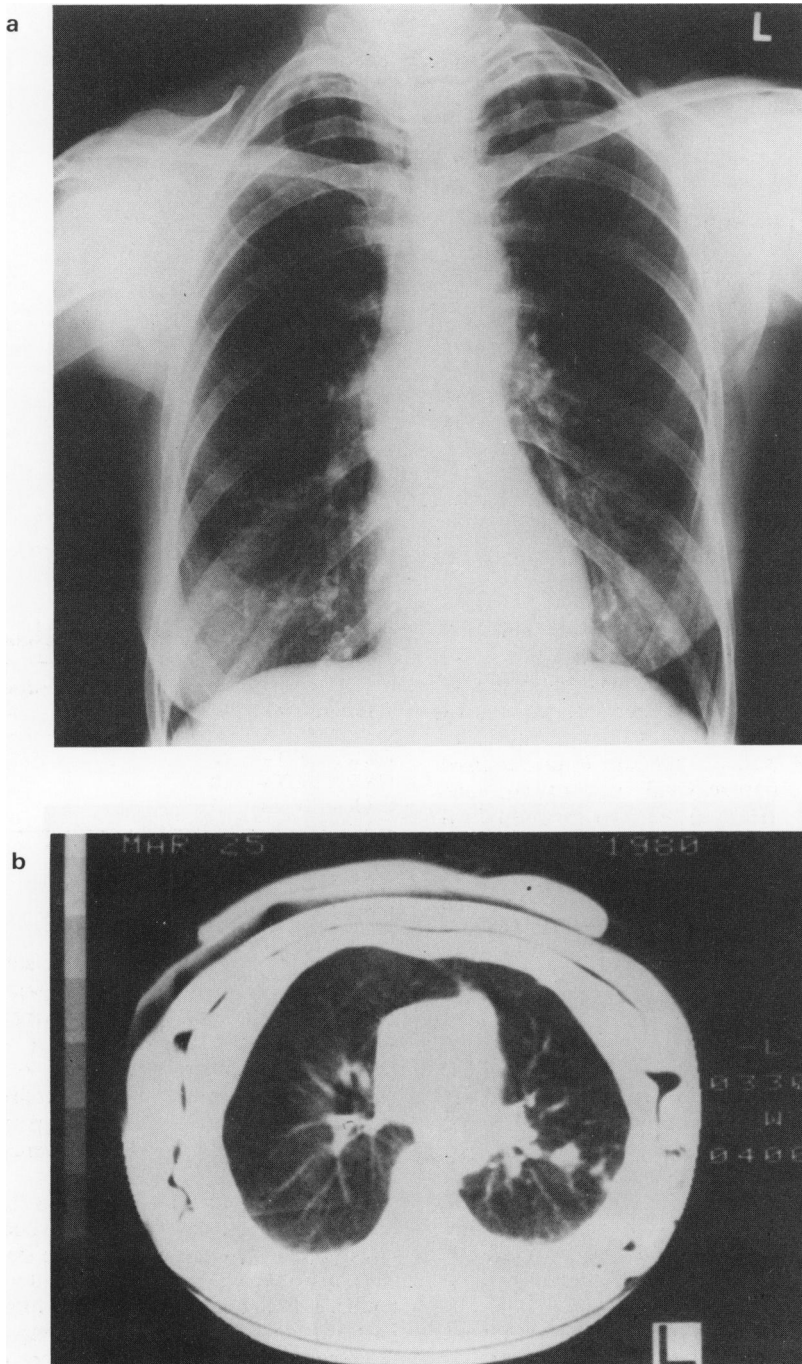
Female age 65 with NHL. (a) CXR: Enlarged L hilum but clear lung fields. (b) CT scan: Enlarged L hilum with peripheral nodules confirmed as lymphoma.
